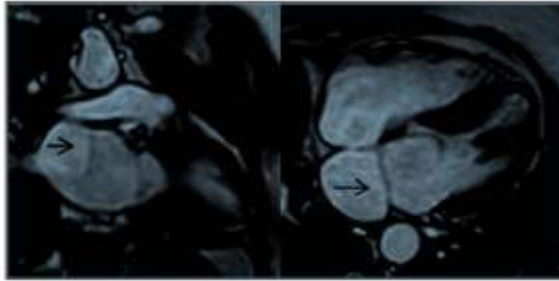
Cine magnetic resonance images using a steady-state free precession sequence clearly depict the mitral valve within the left atrium (arrows); 2-chamber (left) and 4-chamber (right) views.
